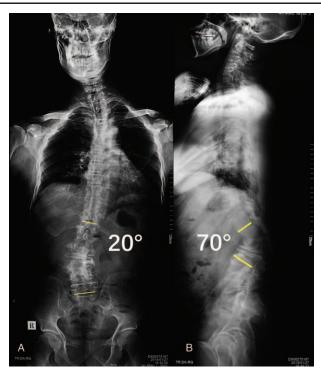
Upright radiographs of the whole spine of the proband's father. (A) Anteroposterior radiograph showing a Cobb angle of 20° at L1 to L5. (B) Sagittal radiograph showing a Cobb angle of 70° at L1 to L3 and with intervertebral space narrowing at L2 to L3.
